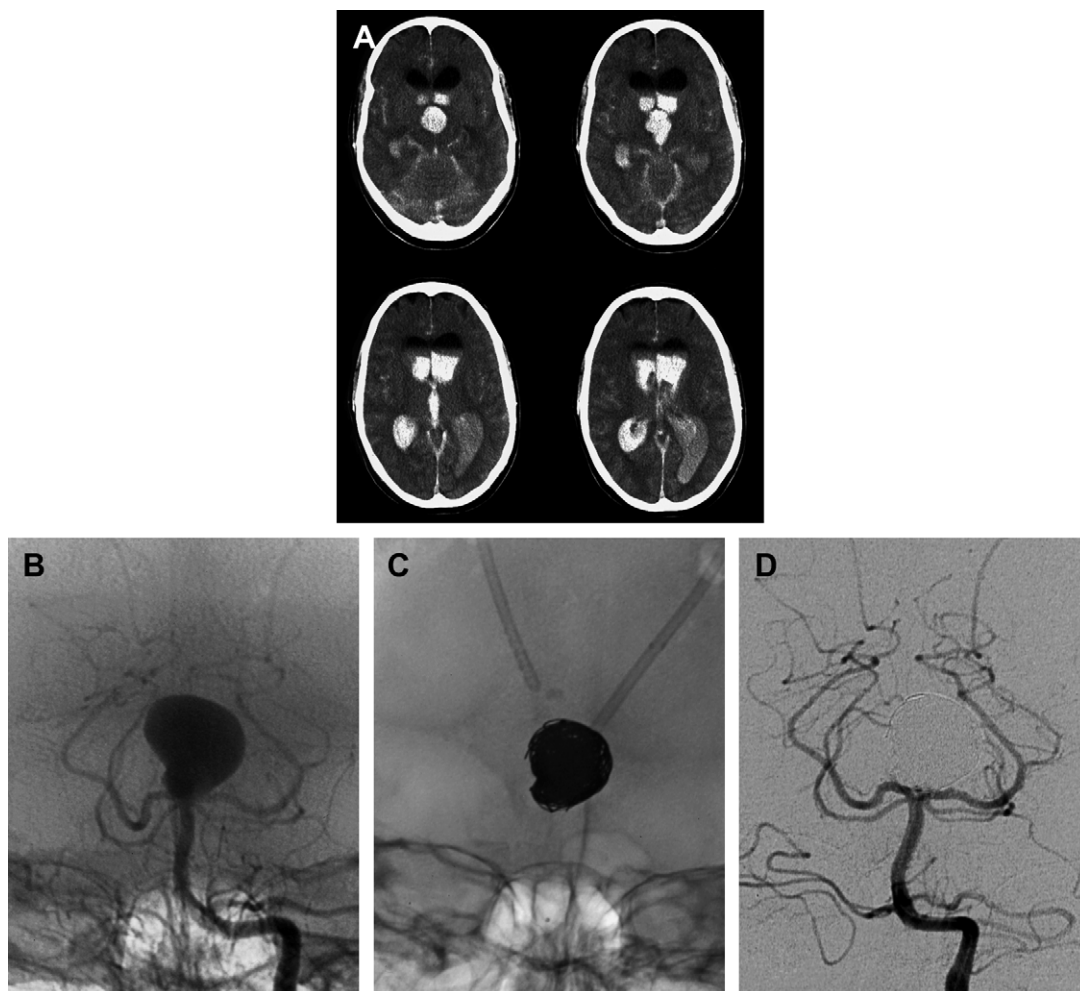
A 45-year-old comatose patient with SAH and IVH. (A) Head CT documenting diffuse SAH and IVH. The patient was transferred to the authors' institution for further management. (B) DSA, transfacial view, showing a large basilar tip aneurysm. (C) Nonsubtracted image of the pack of microcoils (bare platinum coils). (D) DSA, transfacial view after treatment. Mild irregularity is observed at the neck, but there is no residual opacification of the aneurysmal cavity. At the 2-year follow-up visit, her neurologic examination was notable only for memory and cognitive changes.
